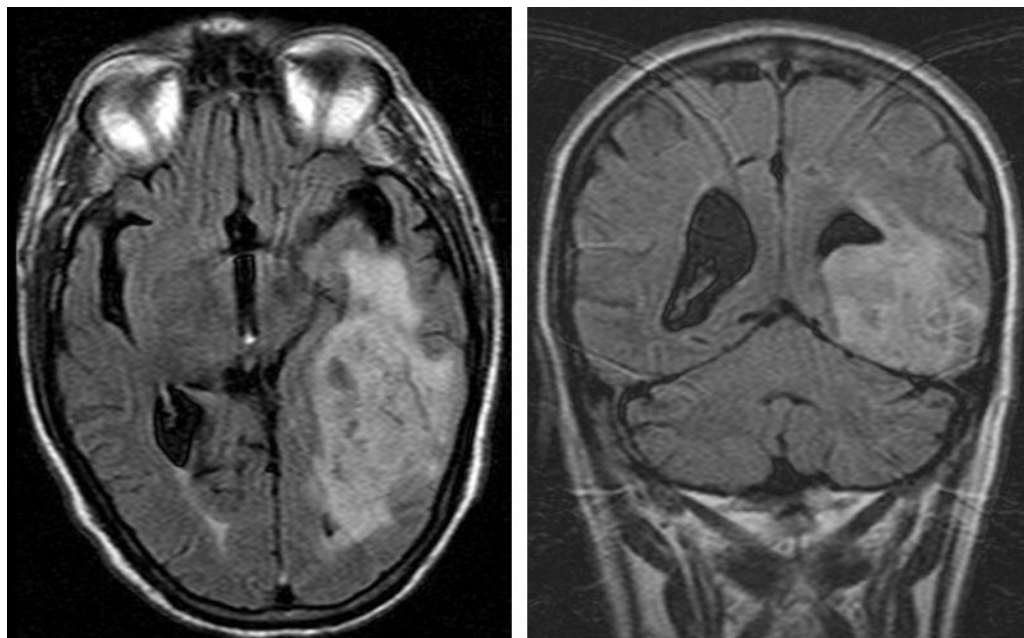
Axial (a) and coronal (b) fluid-attenuated inversion recovery MR images demonstrate the mass with a large amount of surrounding T2 prolongation, a finding that suggests edema.
